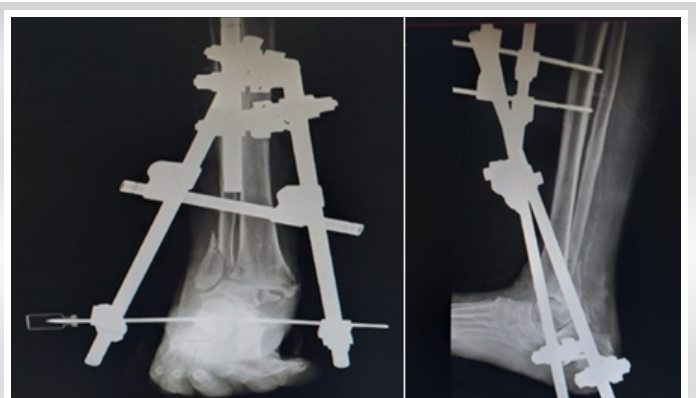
X-ray of right ankle joint (anteroposterior/lateral view) with ankle spanning external fixator.
